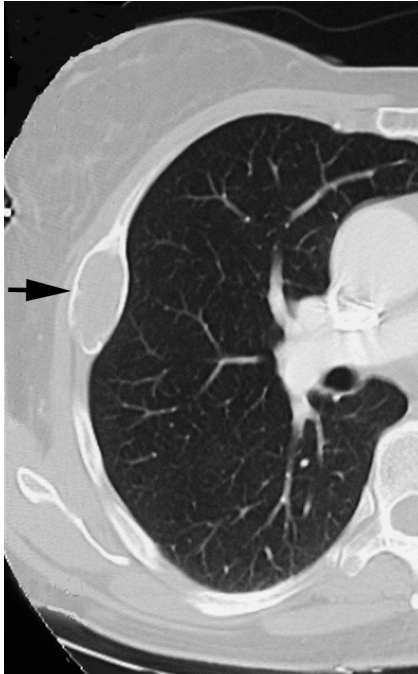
Axial CT scan of the chest showing fibrous dysplasia of the rib (arrow). (Copyright © Rakesh Donthineni-Rao, MD.)
